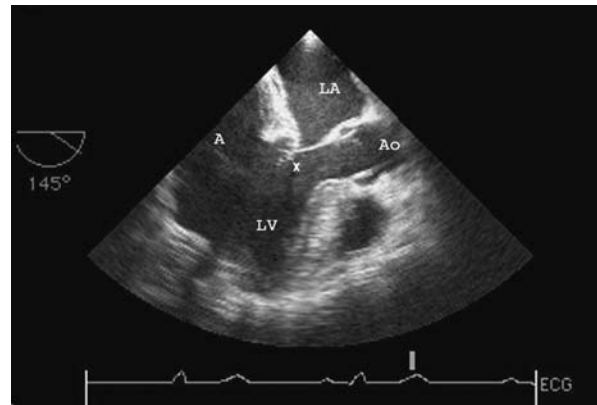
Transesophageal echocardiography shows that the posterior mitral leaflet is tethered by its papillary muscle.
